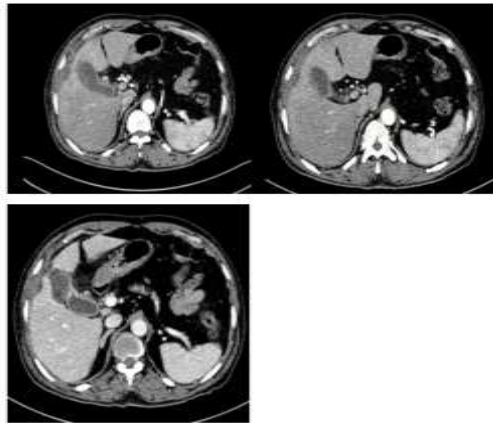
CT scan showing gallbladder perforation with adjacent collection with Cholelithiasis with cholecystitis.
